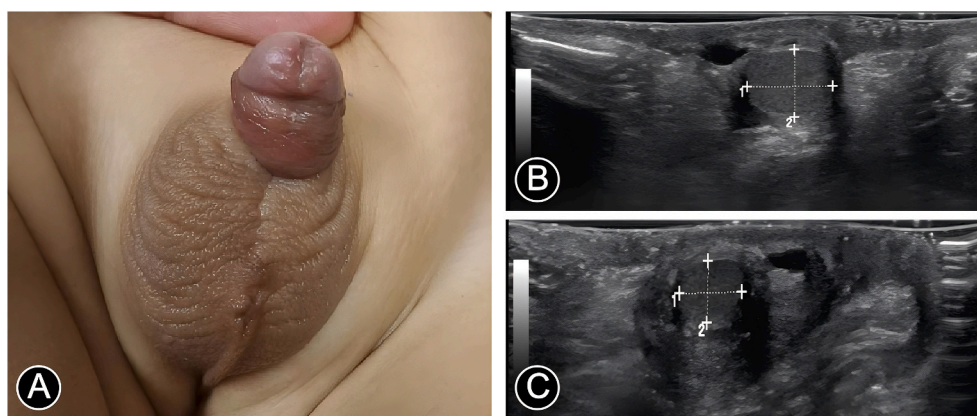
Four-month postoperative follow-up in a child with hypospadias and polyorchidism. A. Surgical site of the penis and scrotum at 4 months postoperatively. B. Ultrasound of the left scrotum at 4-month follow-up. C. Ultrasound of the right scrotum at 4-month follow-up.
